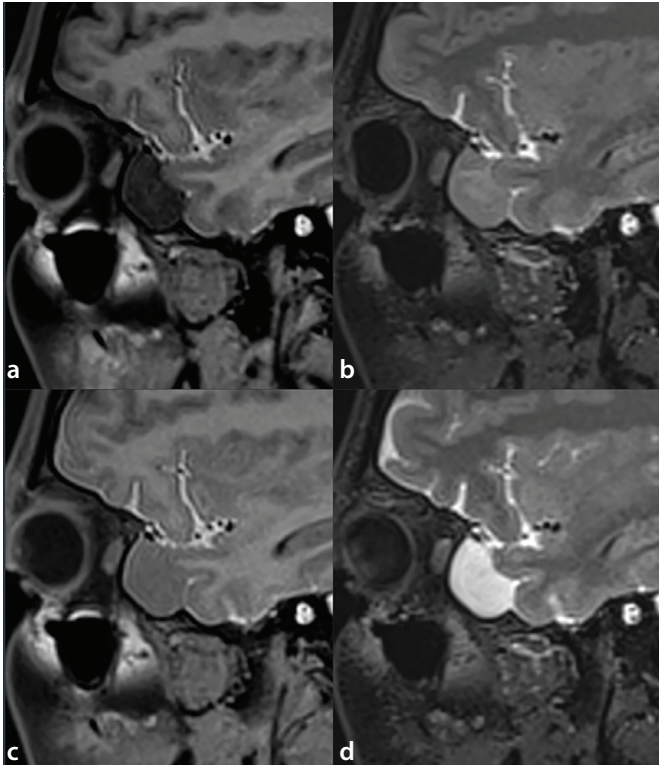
Example of a middle cranial fossa IC-AC. The EP-T1 image (a) shows a faint focal signal increase (grade 1). The EP-FLAIR image (b) shows moderate opacification involving most of the cyst (grade 3). The LP-T1 image (c) shows mild partial opacification (grade 2). The LP-FLAIR image (d) shows near-complete opacification (grade 4). AC, arachnoid cyst; IC, incompletely communicating; EP, early phase; EP, early phase; FLAIR, fluid-attenuated inversion recovery; LP, late phase.
